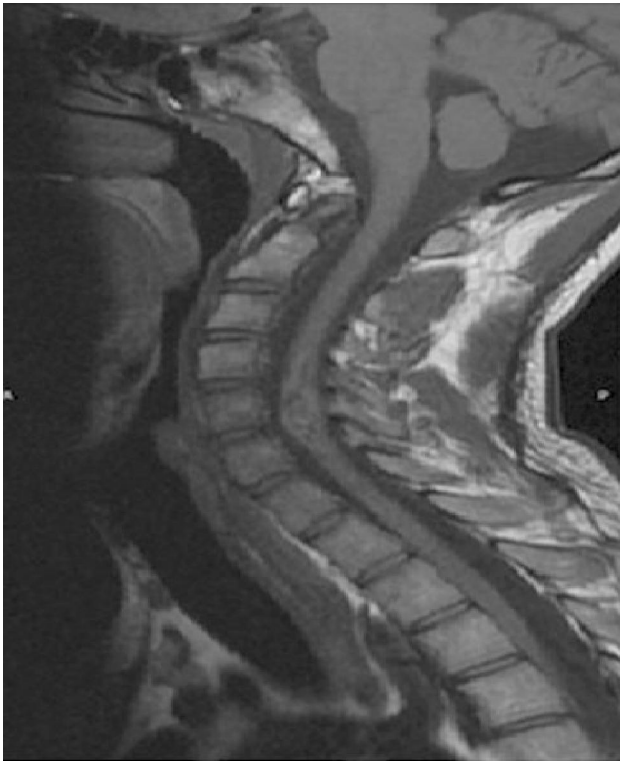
T1-weighted sagittal MR image of cervical spine showing intramedullary heterogenous signal intensity mass with internal hyperintense signals representing hemorrhage at C5-C6 level.
